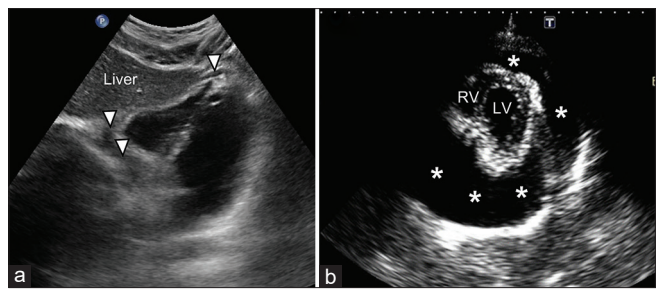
(a) Subxiphoid pericardium view showing physiological pericardial fluid (white arrowheads) – negative FAST, (b) anterior intercostal pericardium view showing large pericardial effusion (white asterisks), assumed to be hemopericardium in a significant trauma context – positive FAST. RV: Right ventricle; LV: Left ventricle, FAST: Focused assessment with sonography for trauma
